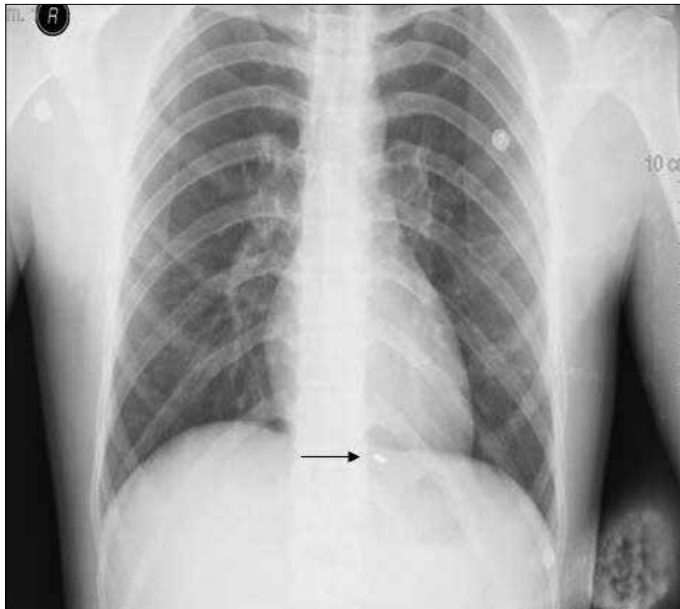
Chest X-Ray image of foreign body (arrow)
